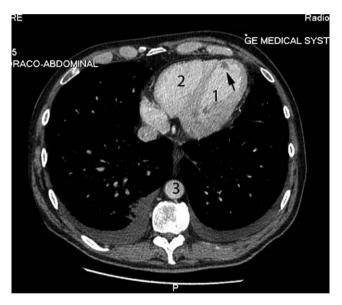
Contrast CT scan, of late arterial phase, shows a cross-section image at the level of the left ventricle. The arrow indicates the thrombus in the apex of the left ventricle. 1: Left ventricle, 2: right ventricle and 3: thoracic aorta.
